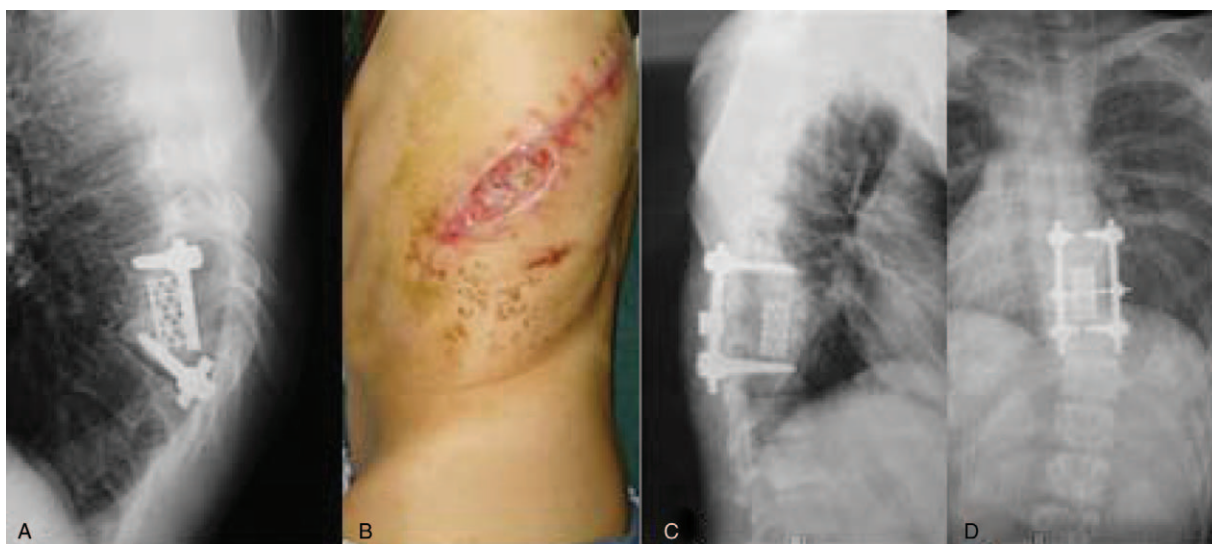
Case 3: A 45-year-old male was diagnosed as tuberculosis recurrence after anterior operation. (A, B) Postoperative x-ray showed fractures of titanium rods and sinus formation. (C, D) Radiographs showed correction of kyphosis and graft fusion after surgical revision.
